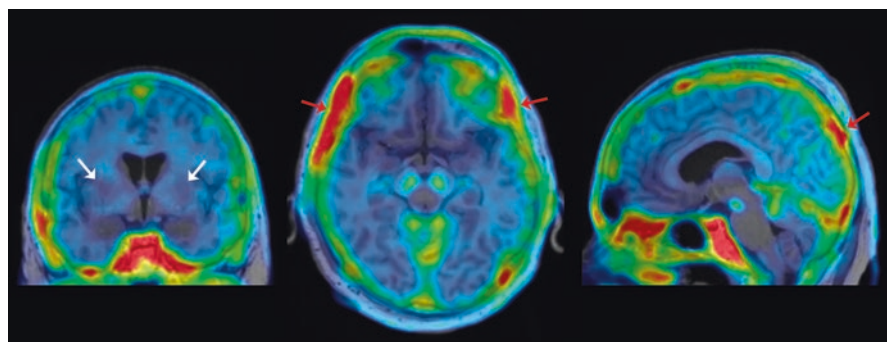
“Nonspecific” uptake with the PET tau tracer ^{18}F -MK6240. From left to right and projected on MRI, coronal, axial, and sagittal ^{18}F -MK6240 images from a cognitively normal 73-year-old man. Please compare it with Fig. 6. Although there is no uptake in the globus pallidus (coronal section, white arrows), there is still uptake in the substantia nigra and uptake in the skull and meninges (red arrows)
